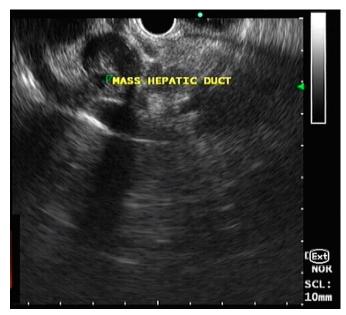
Endoscopic ultrasound image showing a mass in the hepatic duct.
